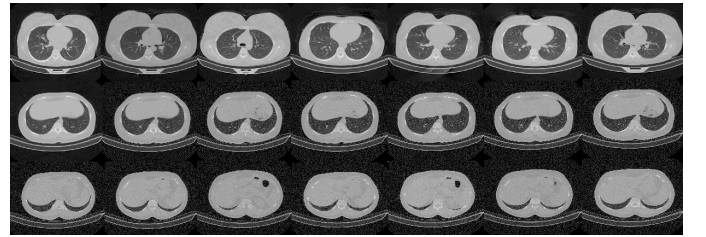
top-to-bottom CT slices of open, partially open and closed lungs.
